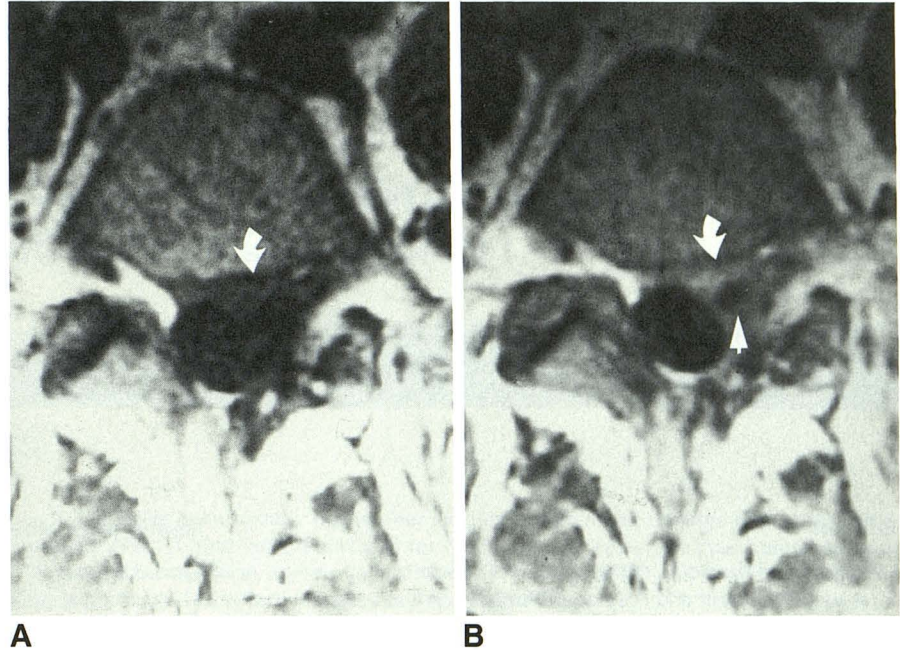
A and B, Enhancement of spinal dorsal root ganglia is shown in pre- (A) and post- (B) Gd-DTPA 800/20/2 MR images. The ganglia (arrows) are less conspicuous after enhancement. In the enhanced image, the ganglion has a higher signal intensity, which is similar to that of adjacent fat.
